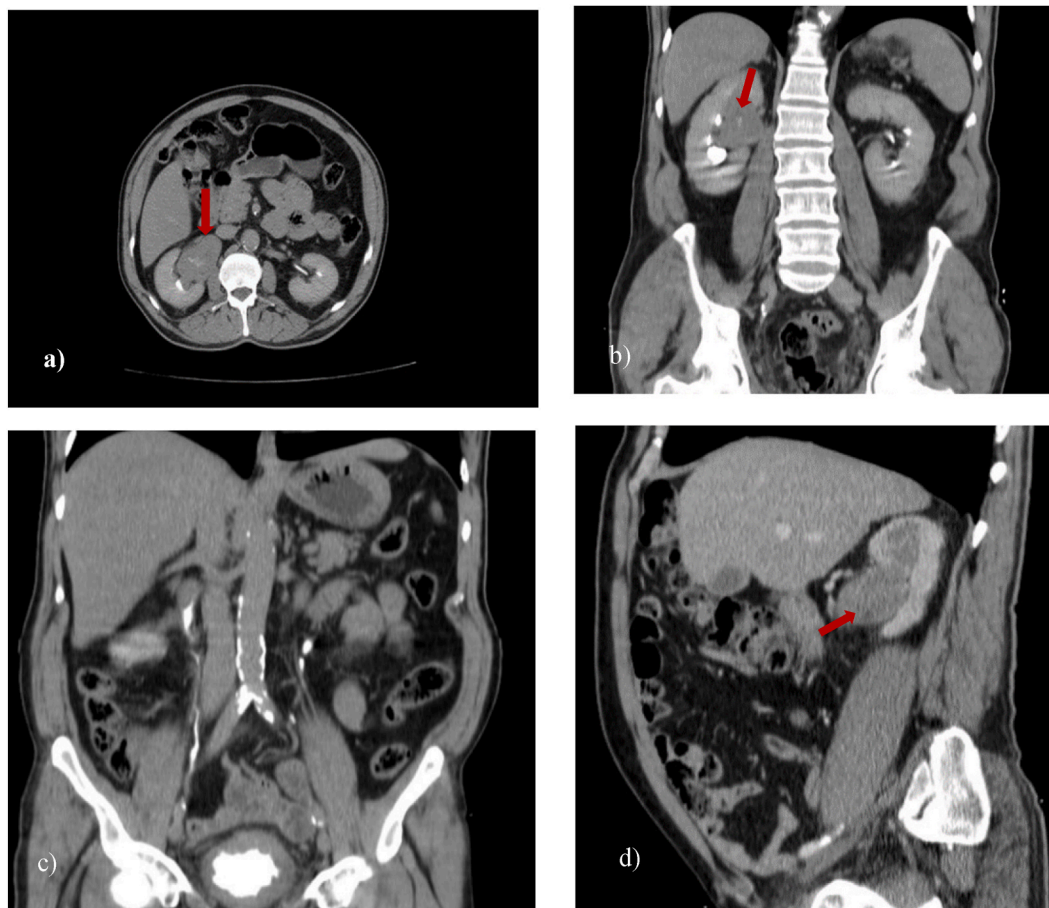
(a–d) CT scans of the abdomen and pelvis delineating a renal lesion. (a) An axial CT scan of the abdomen revealed mild hydronephrosis of the right kidney resulting from a substantial focal lesion (arrow) in the renal pelvis extending from the proximal calyces to the pelviureteric junction (PUJ). (b, c) A coronal sections CT scan of the abdomen and pelvis with contrast, the lesion appeared hypodense (arrow) and exhibited mild enhancement during the delayed phase of the contrast study. The lesion caused significant constriction, resulting in the lumen appearing as a large filling defect. (d) A sagittal section from a CT scan. No enlarged lymph nodes were observed.
